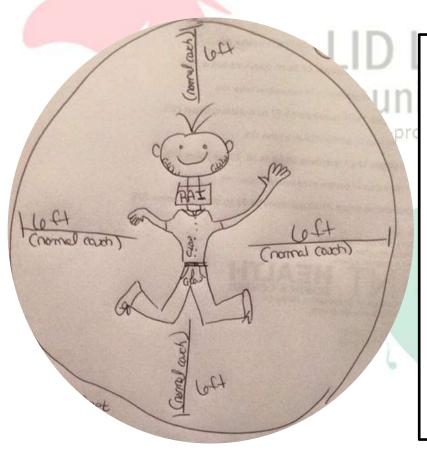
Ray RAI. This is "Ray" and he has a 6 foot glow circle around him, due to Ray temporarily putting out "X-rays" during his isolation. The X-rays do not leave anything bad behind when the glow circle leaves an area. This means that when Ray is near something but does not touch it, it is not contaminated. Ray does have sweaty hands and touched a dresser. He will need to wipe down that area he touched with non-bleach cleaner, such as Lysol or soap & water, at the end of isolation. Ray does have areas that show up in his WBS that are glow areas but not RAI uptake areas. Ray is excreting RAI and it shows in his bladder, GI, and his salivary glands. However, Ray is drinking enough water to pee once an hour and is flushing the RAI from his system.
